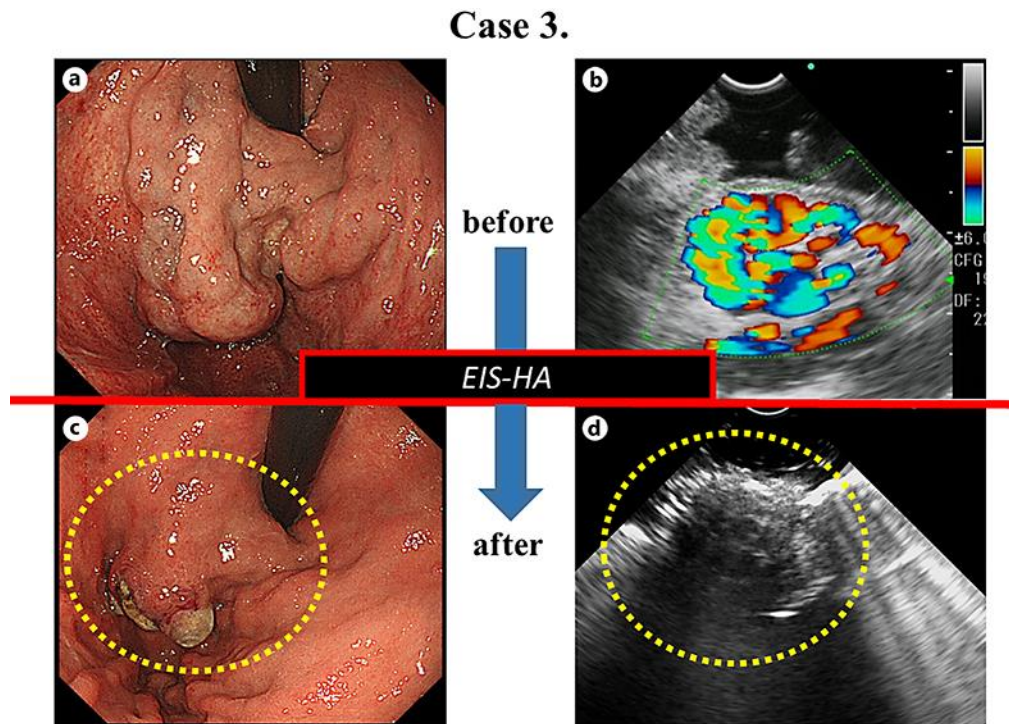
a Endoscopic findings before treatment of case 3. b Endoscopic ultrasound findings before treatment of case 3. c Endoscopic findings after treatment of case 3 (the dotted circle indicates the site of successful treatment). d Endoscopic ultrasound findings after treatment of case 3 (the dotted circle indicates the site of successful treatment).
